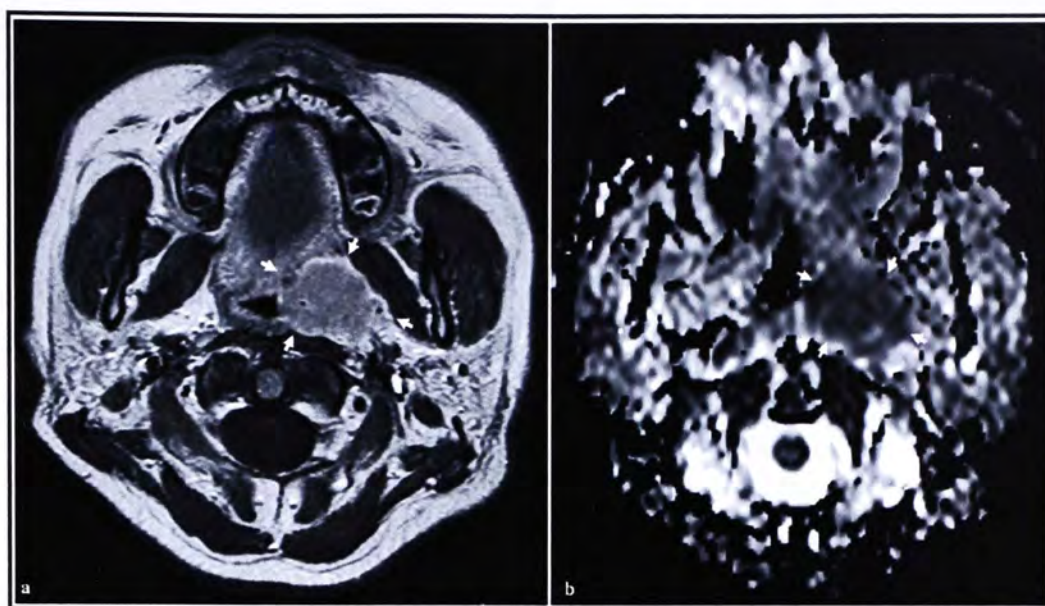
Primary NPC in a 38-year-old woman. The axial post-contrast T1W MR image (left) and ADC map (right) show a primary tumor (arrows) with the ADC value of $0.990 \pm 0.169 \times 10^{-3} \text{ mm}^2/\text{s}$.
